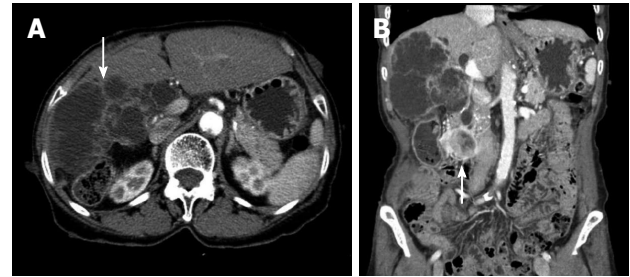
Computed tomography. A: A low-attenuated multilocular mass with septation, and a mural nodule containing a soft tissue-enhancing lesion in the right hepatic lobe (white arrow); B: Diffuse intrahepatic duct (IHD) dilatation, especially in the right hepatic lobe, with a suspicious soft tissue lesion connected to the IHD. A 1.7-cm-sized, well-demarcated enhancing mass is observed in the third portion of the duodenum (white arrow). 300 mm × 225 mm (300 × 300 DPI).
